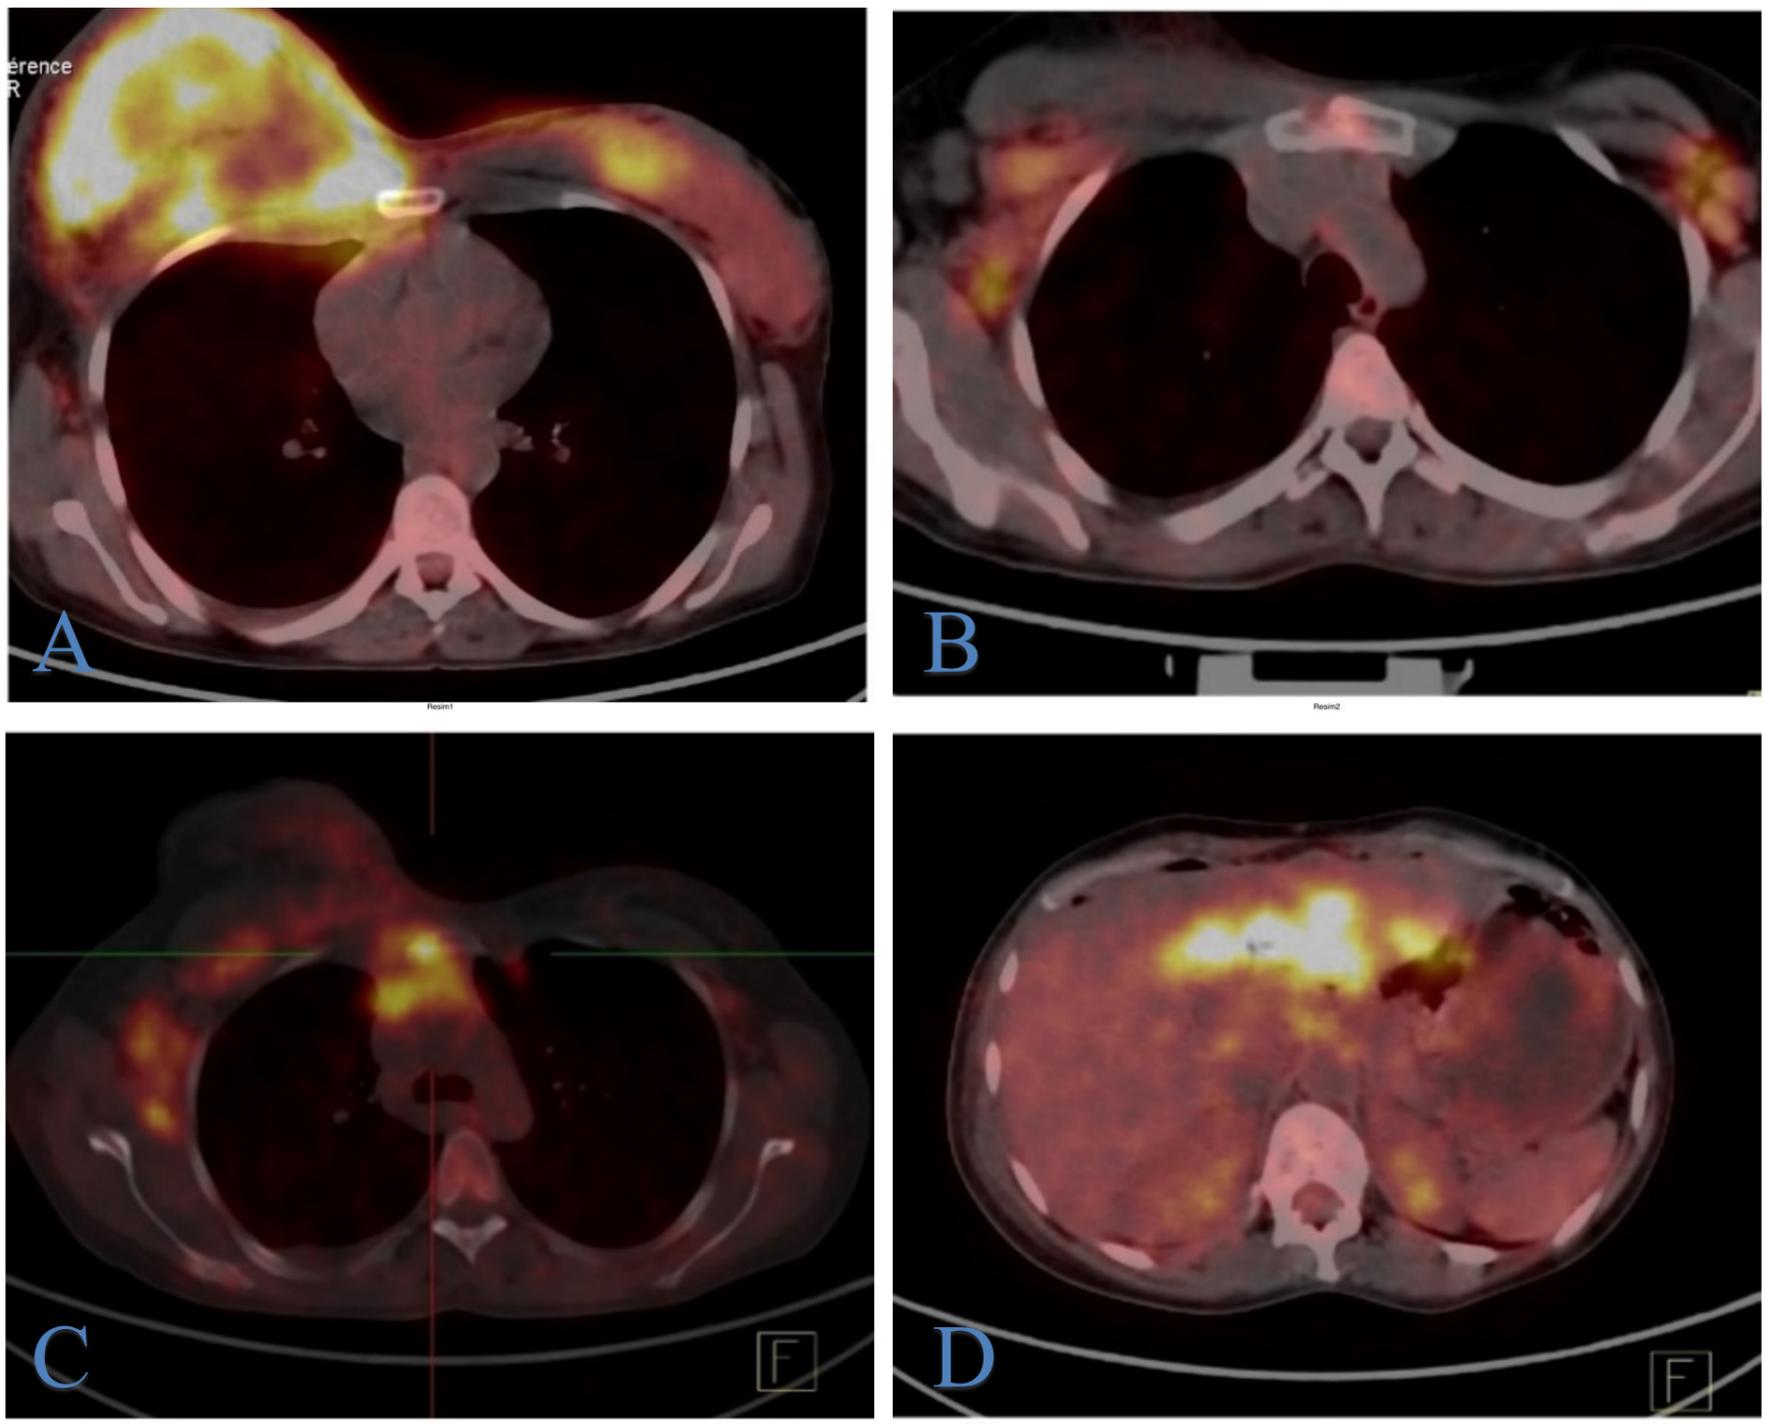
Axial PET/CT images demonstrate bilateral $[^{18}\text{F}]\text{FDG}$ uptake involving both breasts, more pronounced on the right side ($\text{SUV}_{\text{max}} : 8,8 ; \text{MTV} : 521\text{cm}^3$) (A). Bilateral axillary (B), internal mammary and mediastinal lymph node involvement (C), and multiple hepatic nodules (D) were observed, consistent with secondary metastatic disease.
